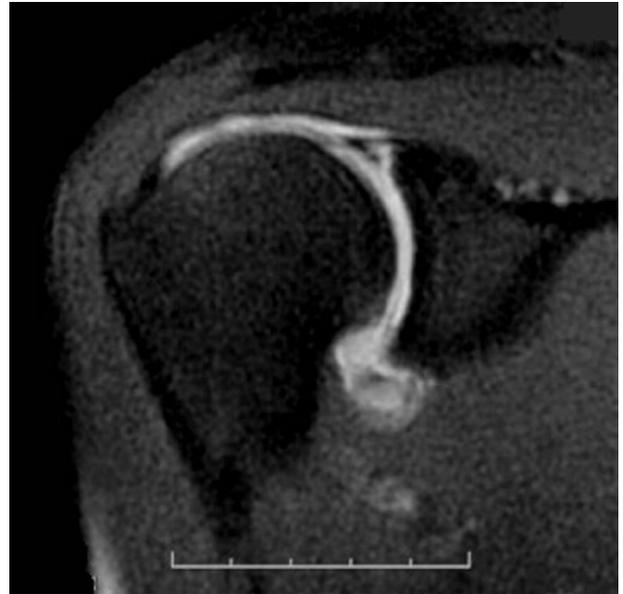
SLAP lesion by magnetic resonance imaging combined with arthrography.
